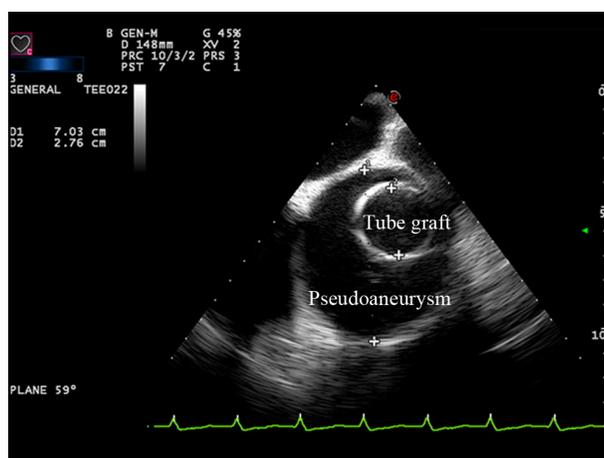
Intraoperative echocardiography before surgical repair: the short-axis view of the aortic tube graft in the ascending aorta with a large pseudoaneurysm surrounding the tube graft. The estimated diameter of the pseudoaneurysm is about 7 cm, compared with the 2.75 cm diameter of the tube graft
